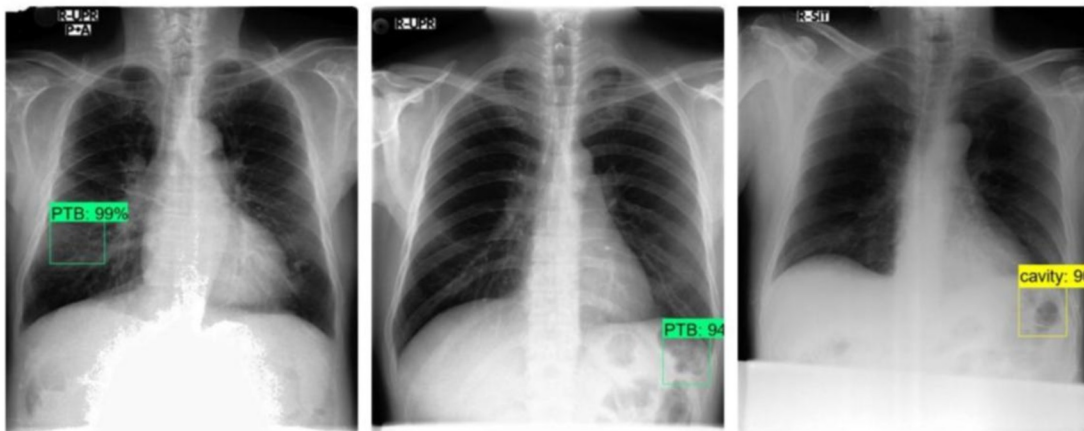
Sample radiographs exhibiting false positives.
